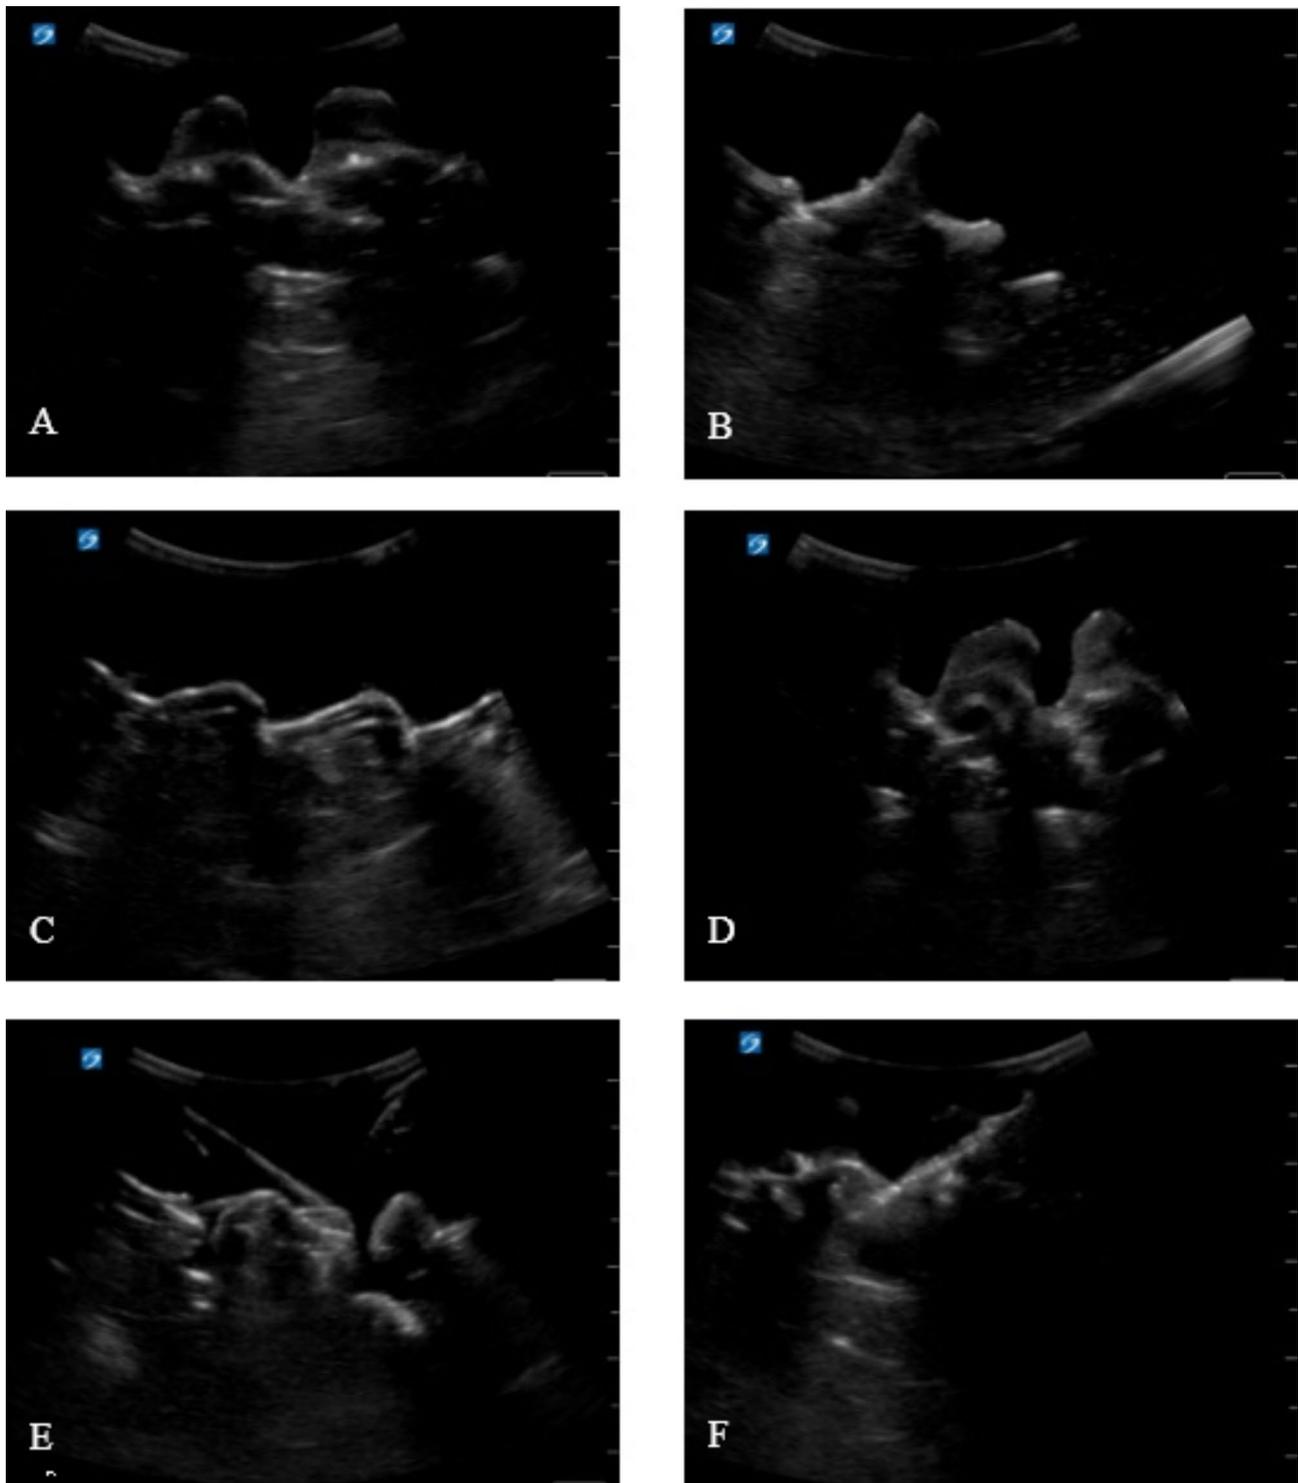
Ultrasound image of a typical puncture plane of the model. Pictures A and B show coronal ultrasound images of the spine; Pictures C and D show sagittal ultrasound images of the spine; Pictures E and F show the ultrasound images of paravertebral puncture
